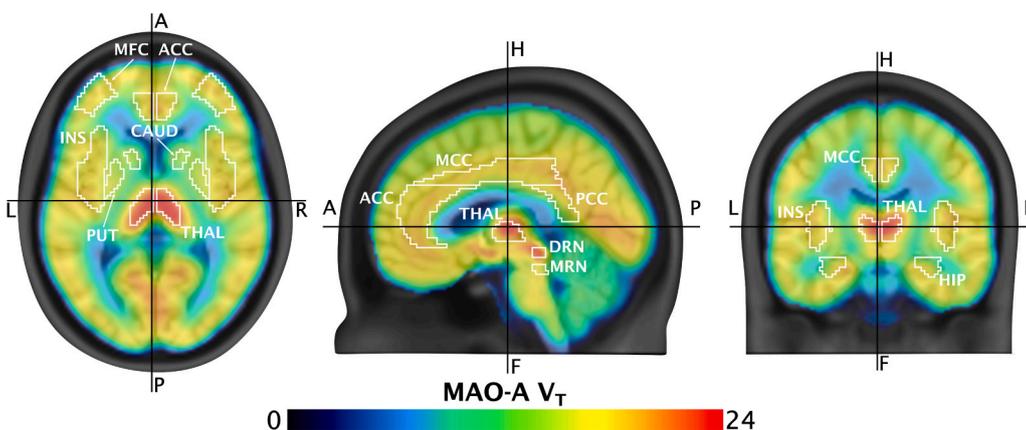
Triplanar sections (axial, sagittal, coronal) of MAO-A distribution volume (MAO-A V_T) in cis-control subjects (17 PET 1 scans) projected on a T1-weighted anatomical MR image in Montreal Neurological Institute standard space (black cross coordinates: $x=-2$, $y=-14$, $z=6$). Regions of interest used for analyses are marked with white borders: middle frontal cortex (MFC), insula (INS), anterior cingulate cortex (ACC), medial cingulate cortex (MCC), posterior cingulate cortex (PCC), hippocampus (HIP), caudate (CAUD), putamen (PUT), thalamus (THAL), dorsal raphe nuclei (DRN) and median raphe nucleus (MRN).
